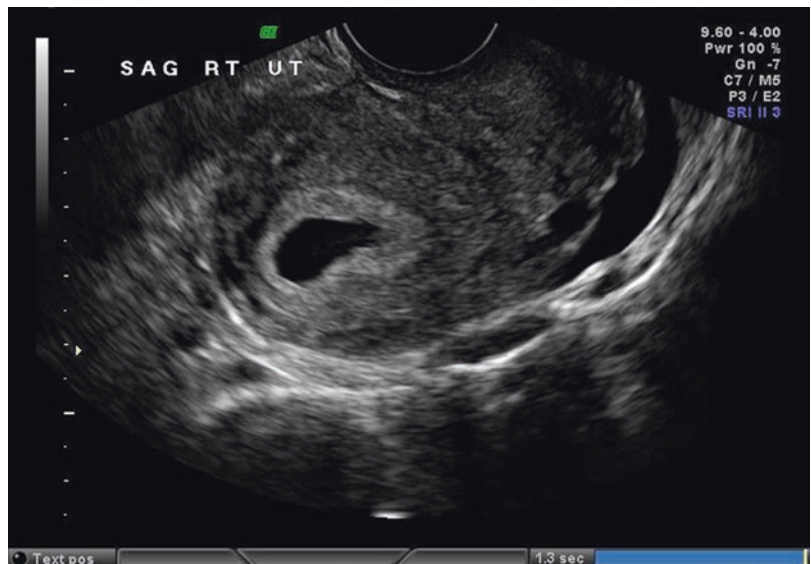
Transvaginal ultrasound: intrauterine pseudosac associated with an ectopic pregnancy
